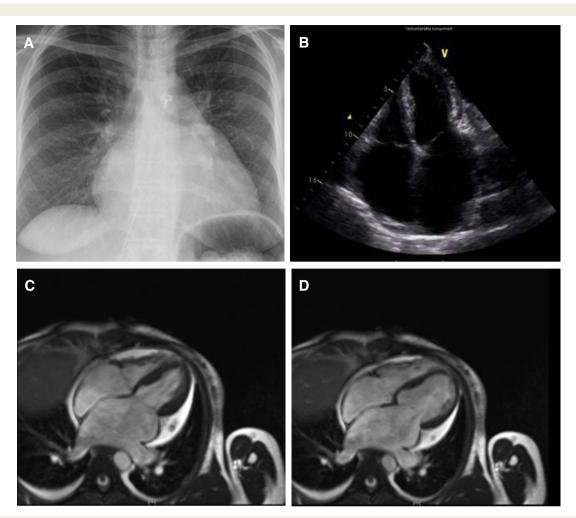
(A) X-ray, (B) echocardiographic and (C, D) magnetic resonance imaging showing gross atrial dilatation.
